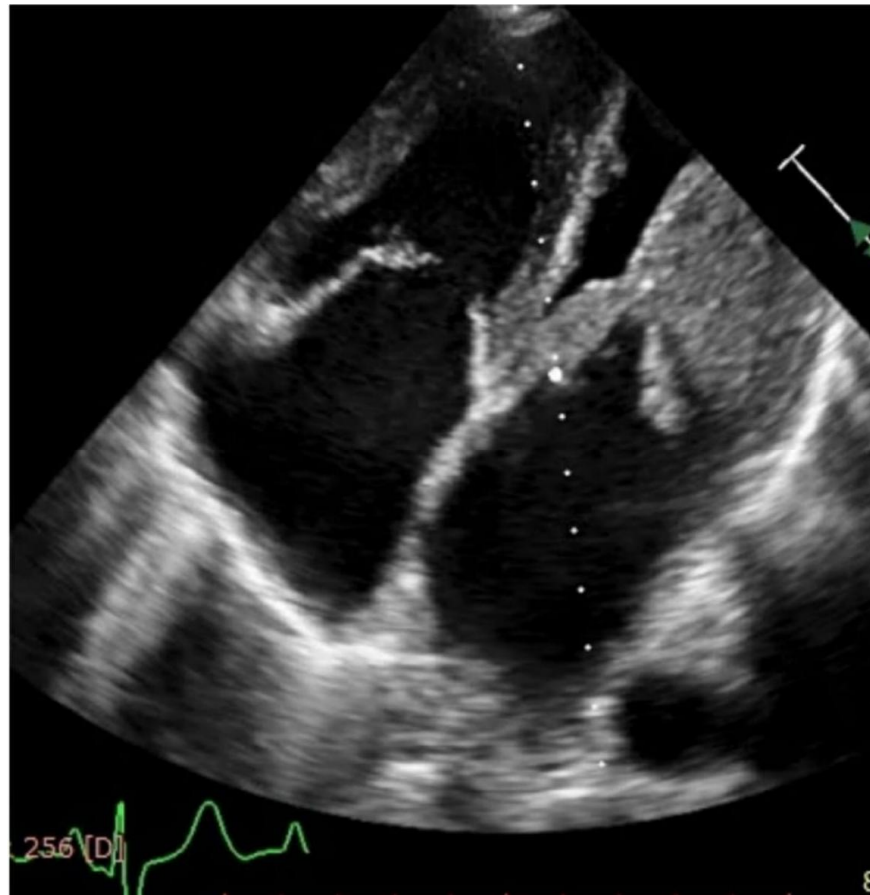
Transthoracic echocardiography apical 4 chamber view showing homogenous mass attached to lateral wall of left ventricle
